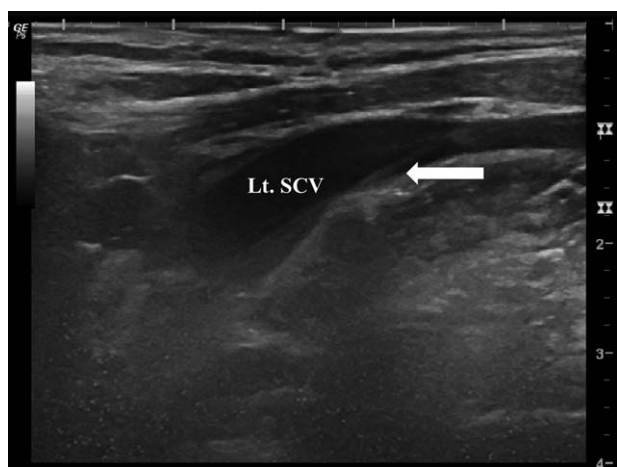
The ultrasonography of left subclavian vein. A needle (white arrow) inserted with supraclavicular approach. Lt. SVC=left subclavian vein.
